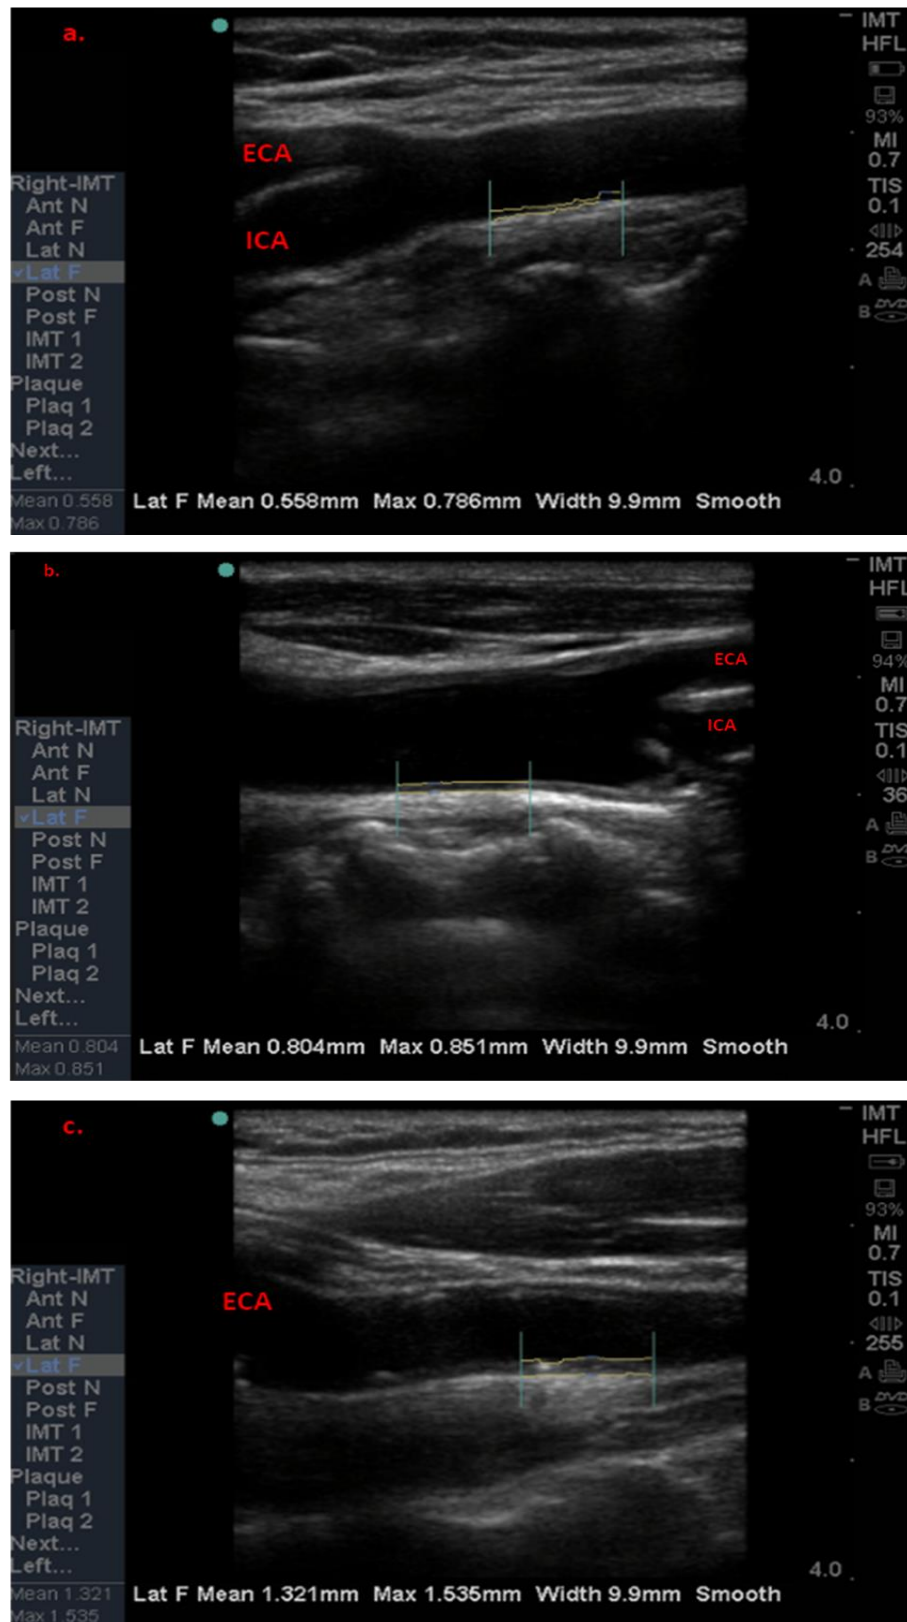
Ultrasonography showing three different carotid intima-media thickness measurements from three patients with critical limb ischaemia. a, IMT=0.558 mm; b, IMT=0.804; c, IMT=1.321 mm. ICA, internal carotid artery; ECA, external carotid artery.
